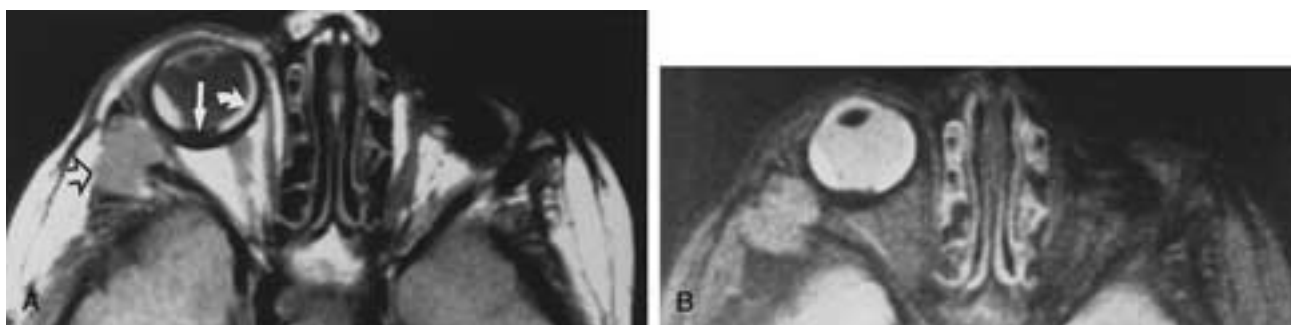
Exudative retinal detachment and regressed retinoblastoma after radiation therapy. A, Axial PW and B, T2-weighted MR images. A and B show a mass (*white arrow*) and a hyperintense subretinal exudate (*curved arrows*). The mass is hypointense in PW and T2-weighted MR images because of calcification. Note the destructive lesion (*open arrow*), presumably a sarcoma, that developed in the field of radiation therapy. The left eye has been enucleated in this patient, who had bilateral Rb.
